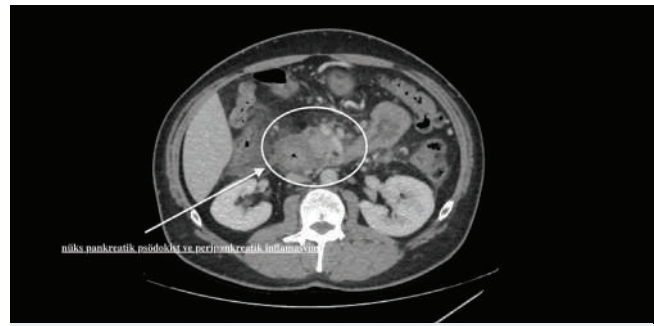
Contrast-enhanced computed tomography showing a recurrent pancreatic pseudocyst. Contrast-enhanced abdominal computed tomography demonstrates a recurrent pancreatic pseudocyst located at the body–tail region of the pancreas, accompanied by marked ductal dilatation and surrounding peripancreatic inflammatory changes.
